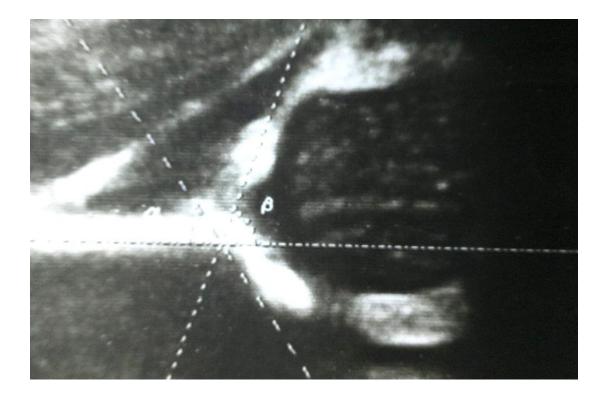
An ultrasound image of current study showing a 16 day-old-boy with Graf Type-IV with Alpha-40 & beta 88 (Dislocated Hip-Interrupted Labrum).
